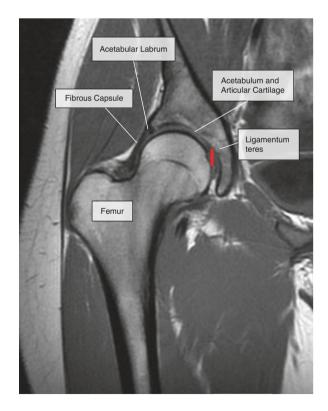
Coronal T1 MRI of the right hip demonstrating the anatomy of a normal hip joint
